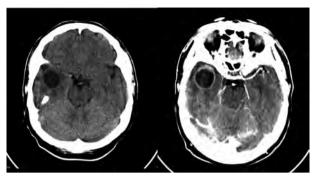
Cranial computerised tomography (CT) with roundshaped hypodense lesion in the right temporal lobe, perilesoinal oedema and mass effect with ring enhancement after contrast.
